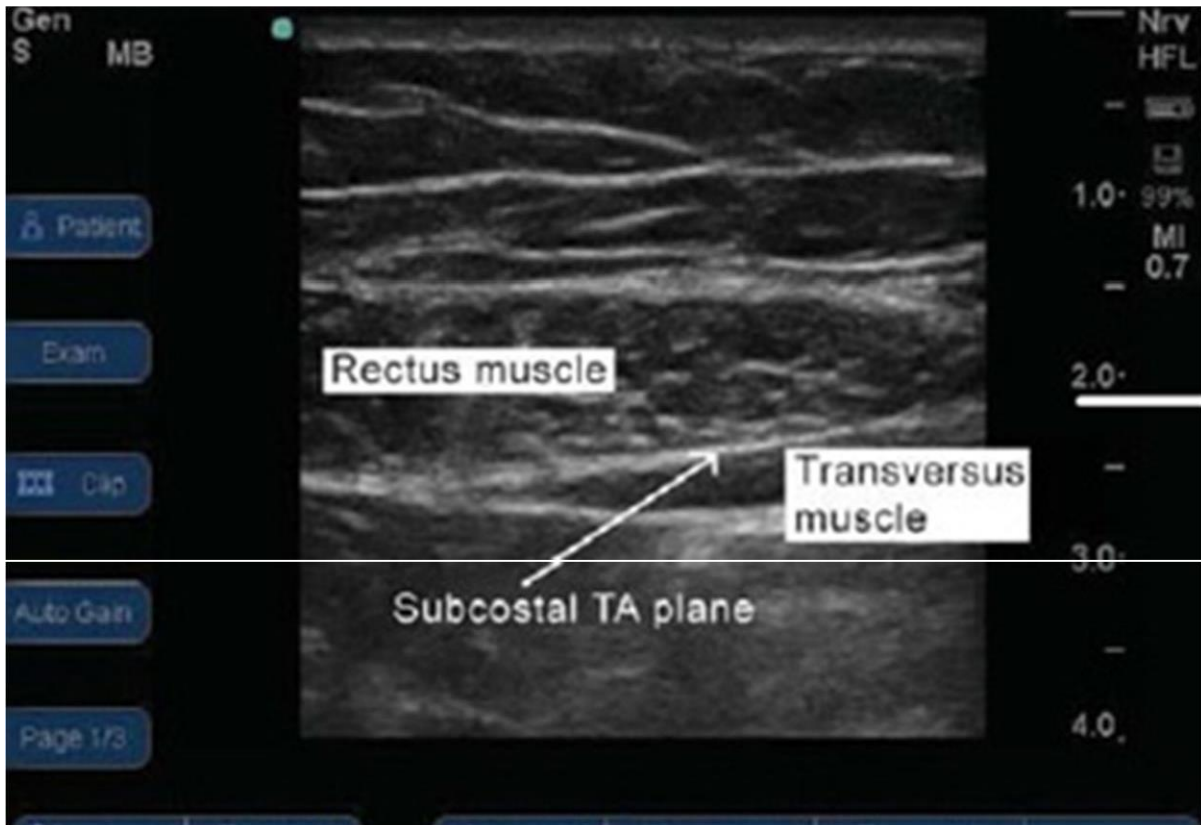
TAP BLOCK ULTRASOUND IMAGE
